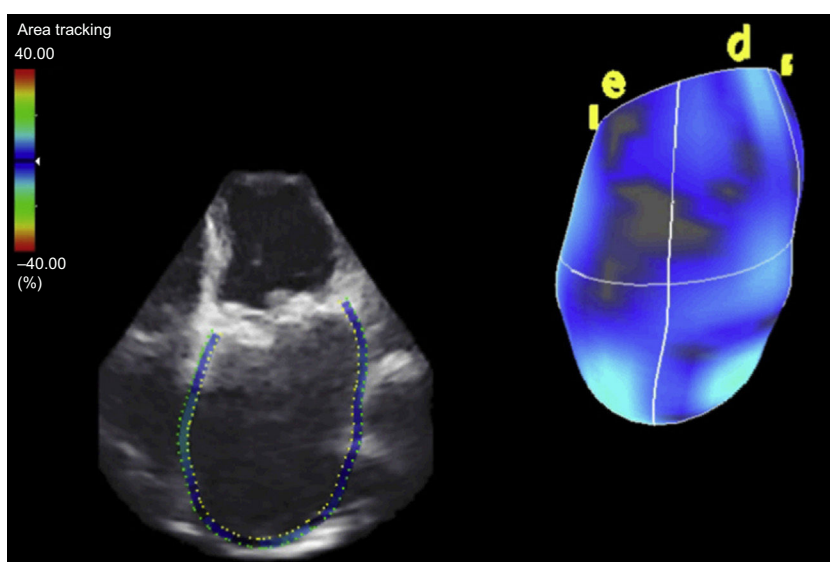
Quantification of left atrial volume by 3-dimensional transthoracic echocardiography.
